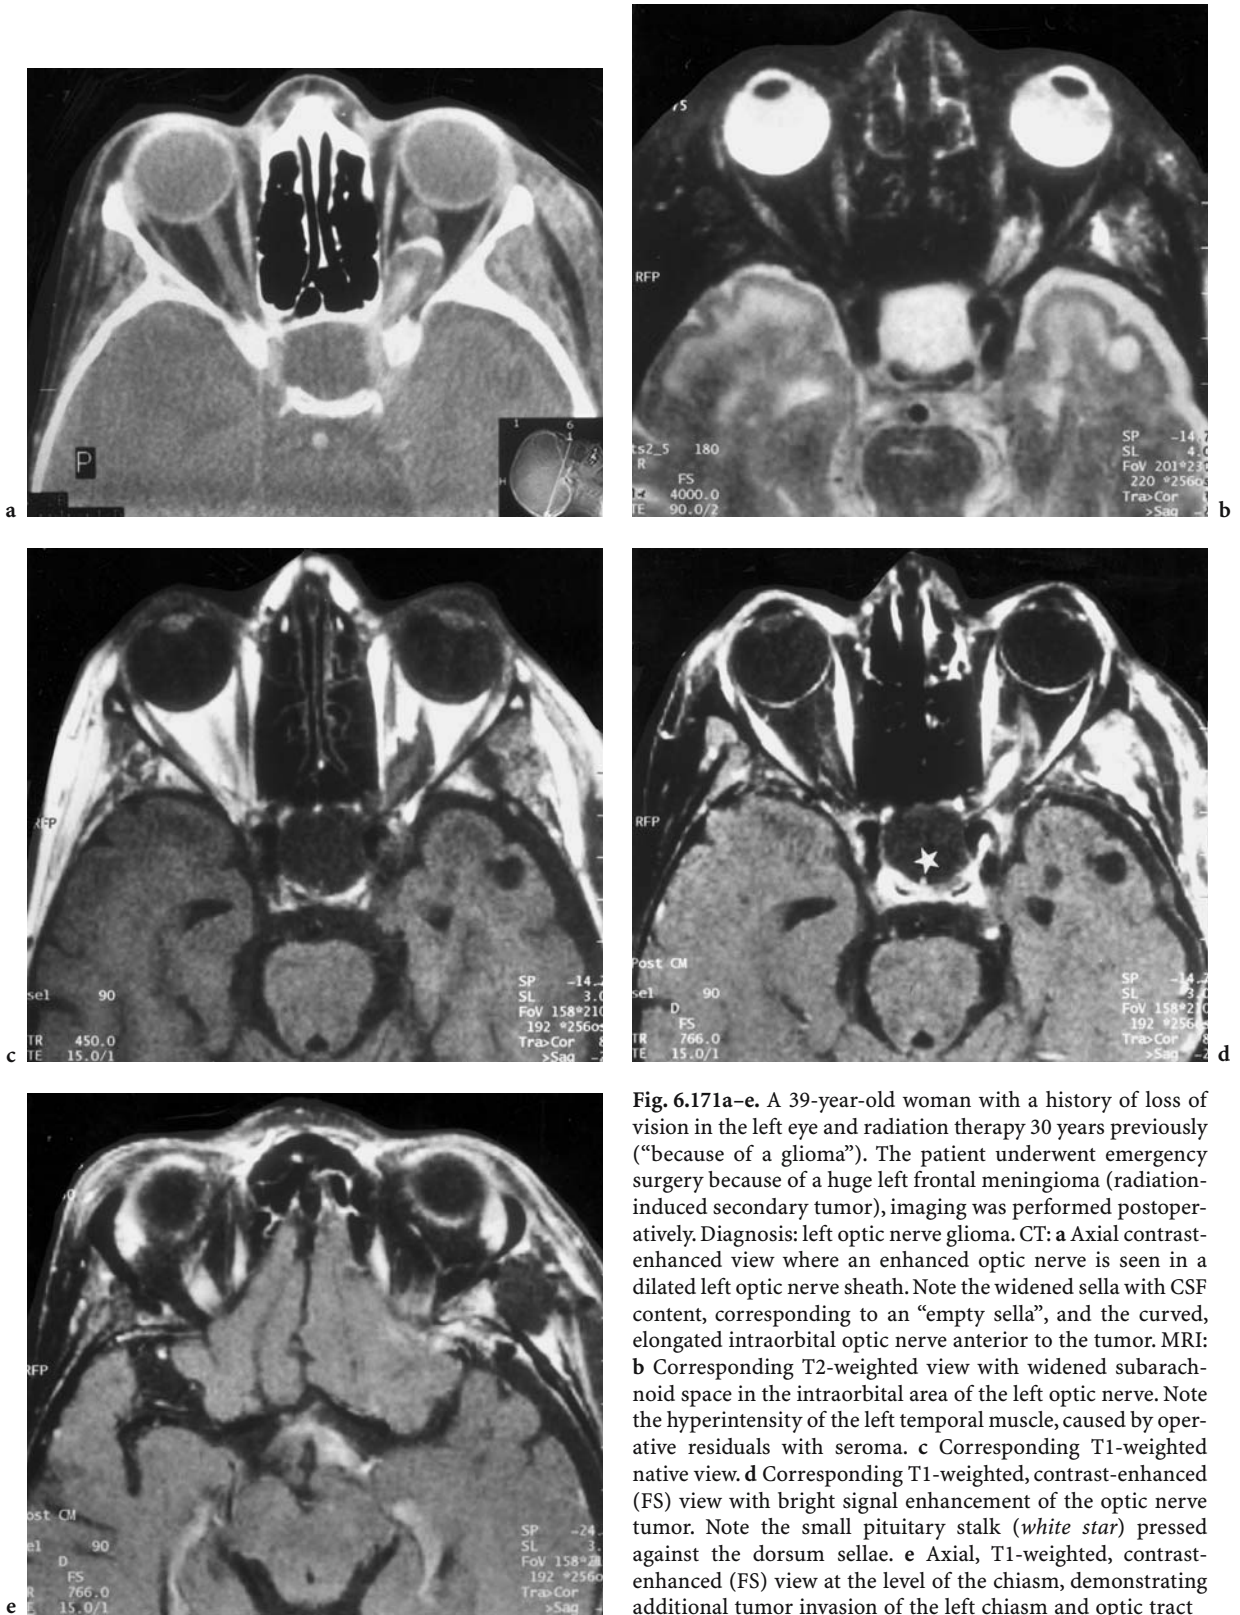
A 39-year-old woman with a history of loss of vision in the left eye and radiation therapy 30 years previously (“because of a glioma”). The patient underwent emergency surgery because of a huge left frontal meningioma (radiation-induced secondary tumor), imaging was performed postoperatively. Diagnosis: left optic nerve glioma. CT: a Axial contrast-enhanced view where an enhanced optic nerve is seen in a dilated left optic nerve sheath. Note the widened sella with CSF content, corresponding to an “empty sella”, and the curved, elongated intraorbital optic nerve anterior to the tumor. MRI: b Corresponding T2-weighted view with widened subarachnoid space in the intraorbital area of the left optic nerve. Note the hyperintensity of the left temporal muscle, caused by operative residuals with seroma. c Corresponding T1-weighted native view. d Corresponding T1-weighted, contrast-enhanced (FS) view with bright signal enhancement of the optic nerve tumor. Note the small pituitary stalk (*white star*) pressed against the dorsum sellae. e Axial, T1-weighted, contrast-enhanced (FS) view at the level of the chiasm, demonstrating additional tumor invasion of the left chiasm and optic tract
